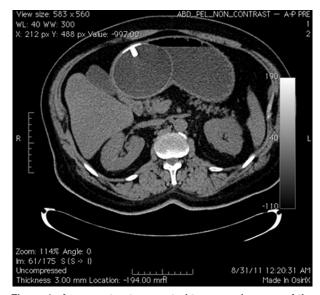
A noncontrast computed tomography scan of the abdomen showing a rounded, fluid-filled device within the gastric antrum, measuring 9.9 cm \times 8.3 cm \times 9.1 cm, causing gastric outlet obstruction.
